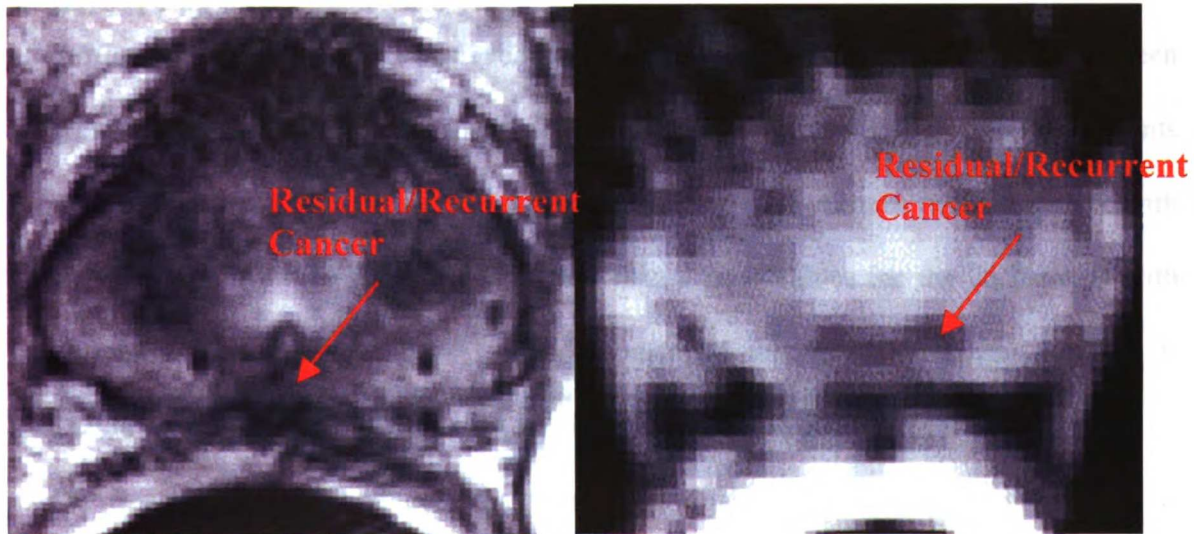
T2-weighted MRI (left) and $\langle D \rangle$ map (right) following brachy therapy. Cancer was poorly depicted in the anatomic MRI but was clearly delineated in the $\langle D \rangle$ image.
